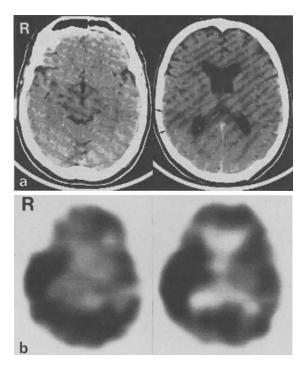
46-year-old male with an embolic stroke 5 days prior to examination. a TCT shows a small cortical and an additional small subcortical infarction in the territory of the right middle cerebral artery. b HMPAO-SPECT demonstrates increased rCBF in the right temporal region
